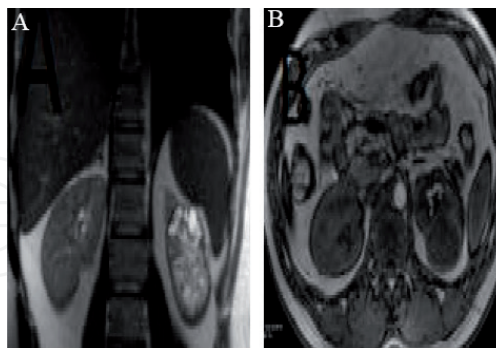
MRI showing hydatid cyst in the lower pole of the kidney: (A) coronal T1 weighted scan and (B) axial T2 weighted scan.
